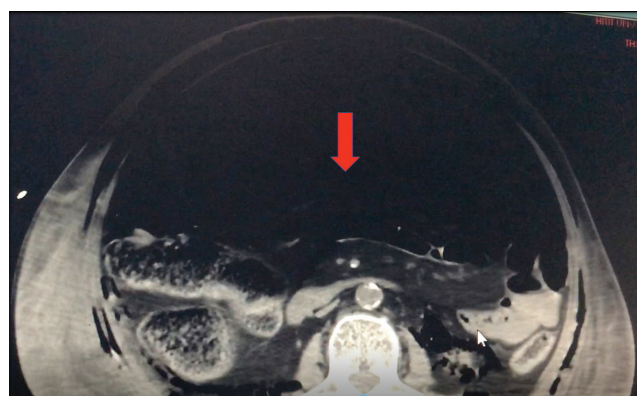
Computed tomography of the abdomen shows massive pneumoperitoneum. Red arrow points to a large amount of free air in the peritoneal cavity and the viscera is pushed posteriorly.
